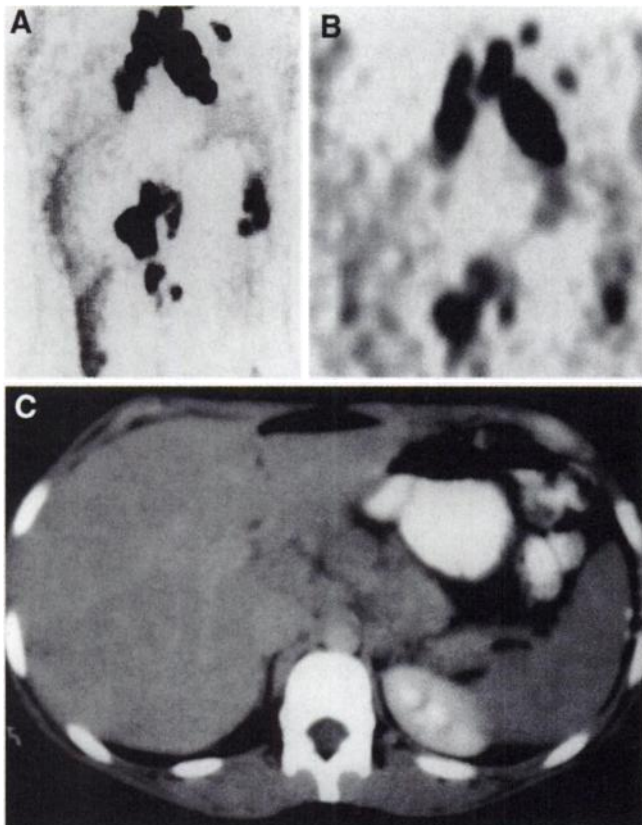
A 21-y-old woman with Hodgkin's lymphoma. Coronal PET (A) and DHC (B) images show similar foci of increased uptake indicating lymph nodes involved by lymphoma (patient A). (C) CT shows retroperitoneal lymph nodes.
